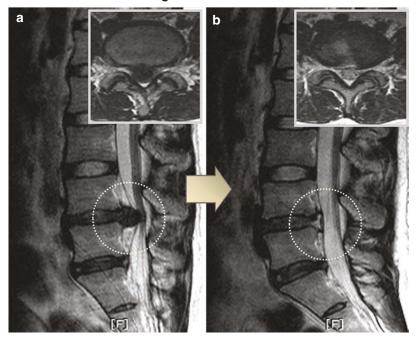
TELD for central disc herniation that required foraminoplasty. Preoperative MRI of a 32-year-old female patient showed severe soft disc herniation located in the central zone of L4-5 level (a, b). TELD was performed after skin entry point determination (e), but access close to
